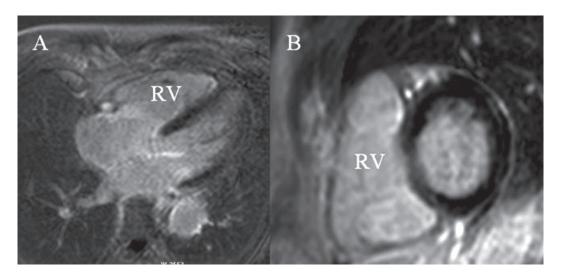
MRI with Delayed contrast enhancement technique revealed no myocardial contrast enhancement of the left ventricle and right ventricle. A: Horizontal long axis view, B: short axis view of both ventricles
